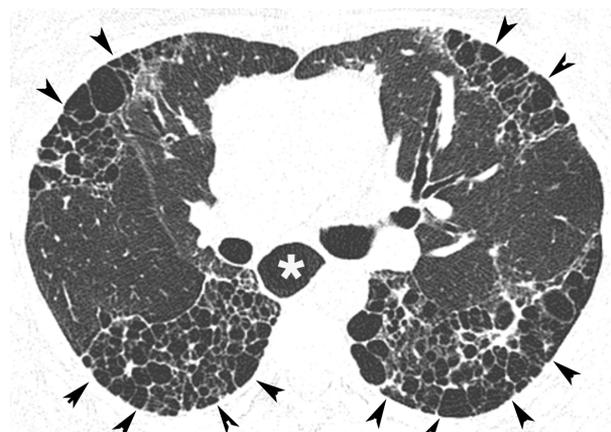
Axial CT scan of the chest at the level of the lower lobes, showing multiple subpleural cysts that share walls and stack upon one another in layers, predominantly in the inferior and posterior portions of the lungs (arrowheads). Note dilation of the distal esophagus (asterisk).
